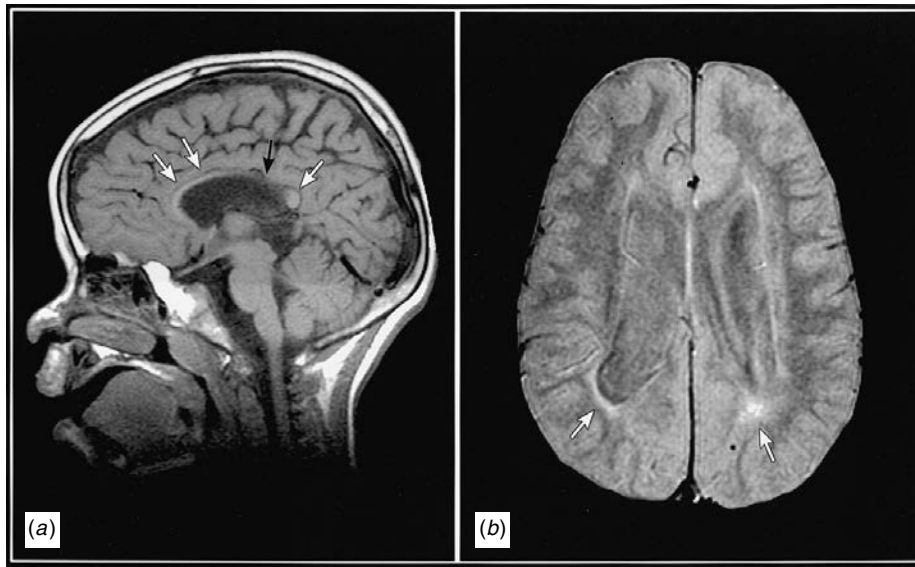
These MR images obtained in childhood show the MR imaging findings of PVL. (a) Marked thinning of the corpus callosum (white arrows) with area of complete loss (black arrow); (b) Ventriculomegaly with scalloped irregular borders and periventricular gliosis (white arrows). Clinically the child had severe motor and cognitive impairments. (These images were previously published in Hoon & Melhem, 2000.)
